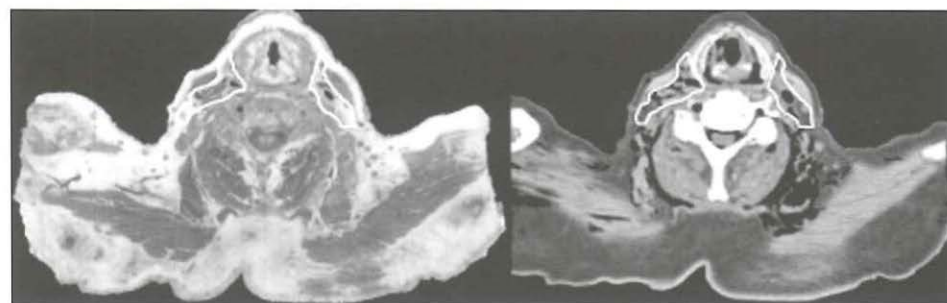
Region 3 (mid-jugular lymph nodes): The borders of this region are outlined on a transversal anatomy slice (left panel) and the matched CT slice (right panel), in between the cranial (hyoid bone) and caudal (one slice below the thyroid cartilage) borders. The borders are discussed in the text and in Table 1.
